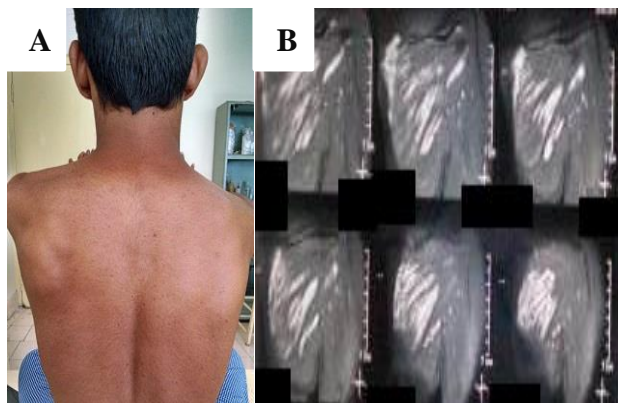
A & B: Hemangioma of left infra-spinatous muscle, MRI.
